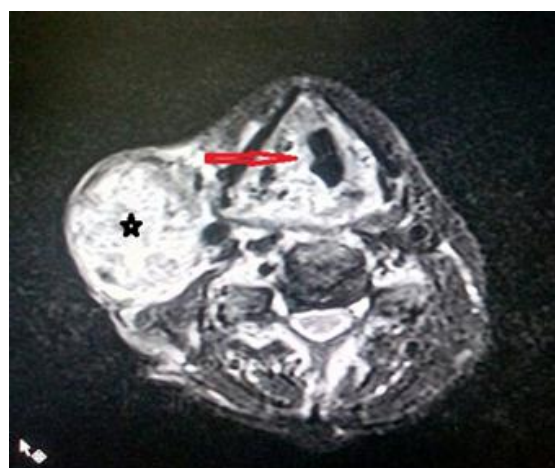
T2 axial MR image showing hyperintense signal intensity mass lesion involving the supraglottic region on right side (red arrow) along with lymph node mass (star).
